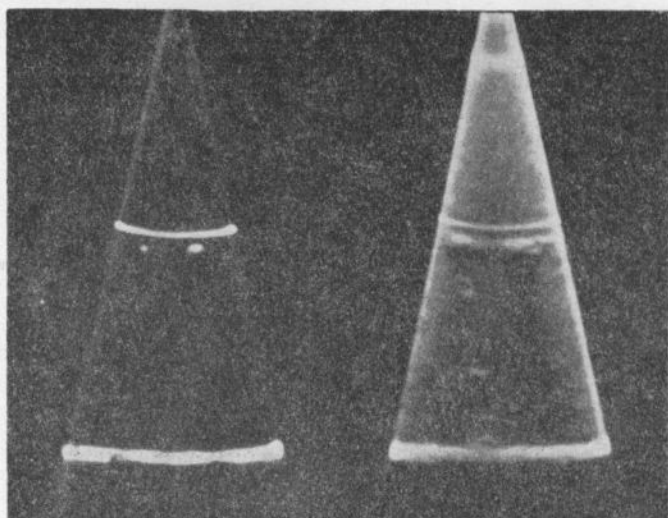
Ultrasonograms of a plasticine sphere pair obtained with the echo method (left picture, low amplification) and with the shadow method (right picture, high amplification). The radius of the left sphere was $a = 1.25$ mm ($ka = 16$); that of the right one, $a = 2$ mm ($ka = 25$)
